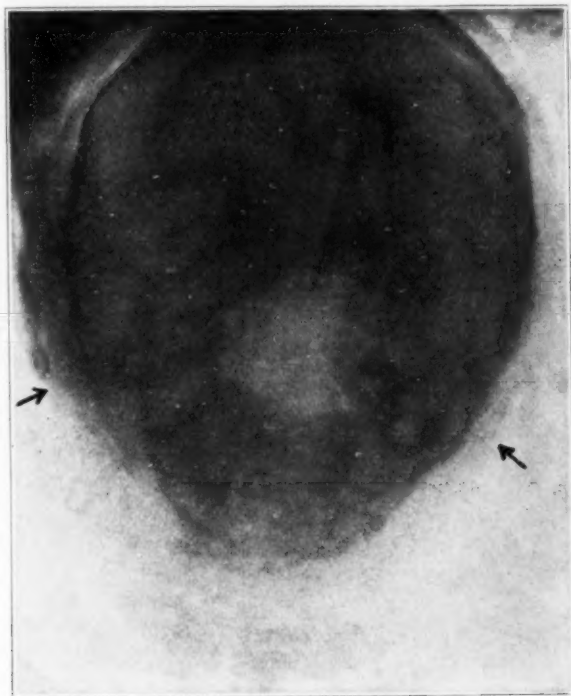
Roentgenogram, showing enlargement of the foramen magnum in child 5 weeks old.
